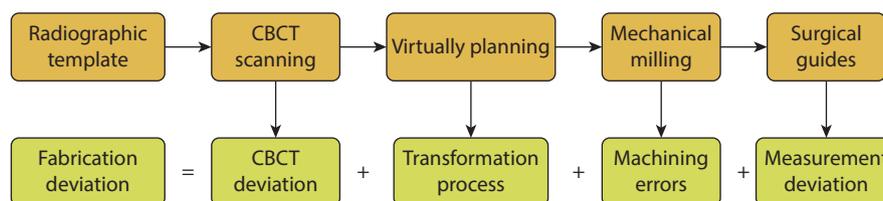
Factors contributing to preclinical deviations of milled implant surgical guide. CBCT, cone beam computed tomography.
